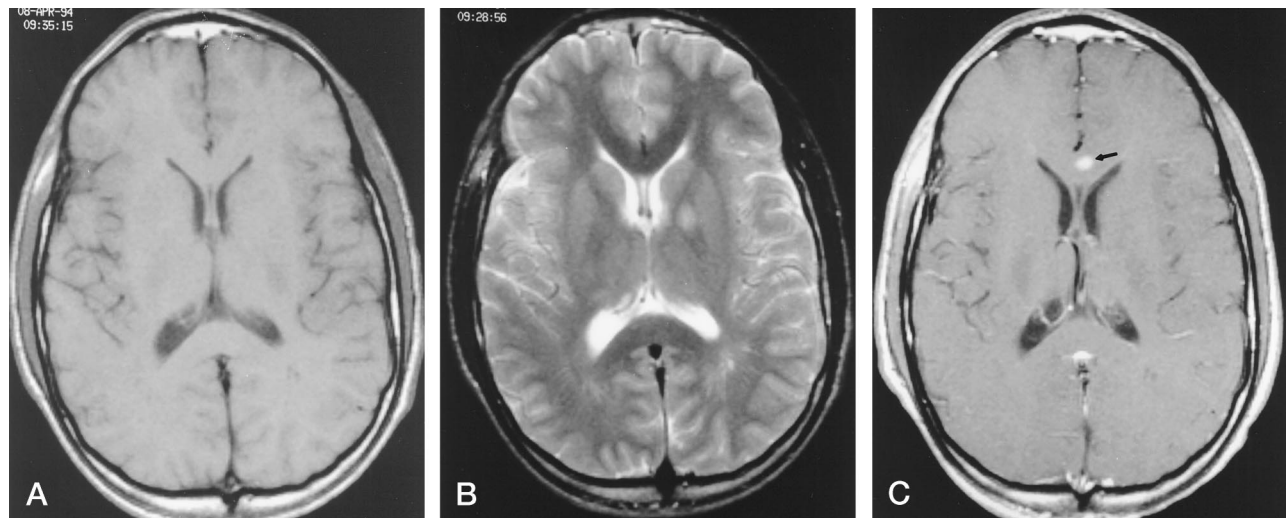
15-year-old asymptomatic boy with presumed astrocytoma detected only on postcontrast MR images.
